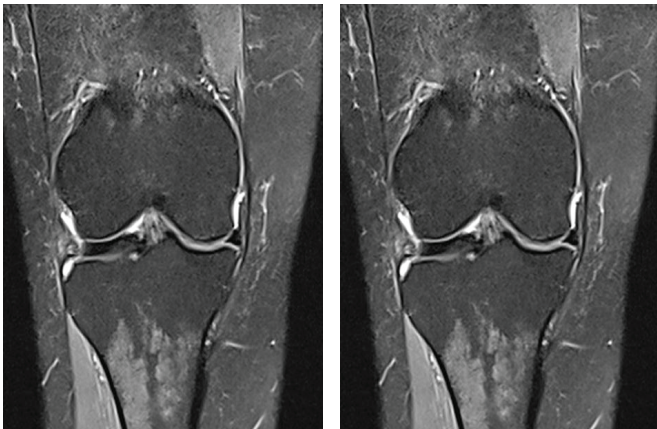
(Discoid lateral meniscus with longitudinal tear): PD Coronal MR image in a 34-year-old female badminton player shows discoid lateral meniscus with a longitudinal tear in anterior horn and adjacent part of the body with marrow edema in proximal tibia.
